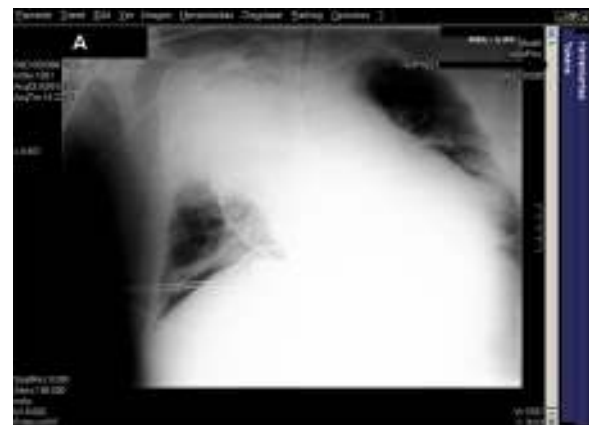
The chest X-ray showed right upper and middle lobes atelectasis. The ultrasound exploration was performed over these lobes.
